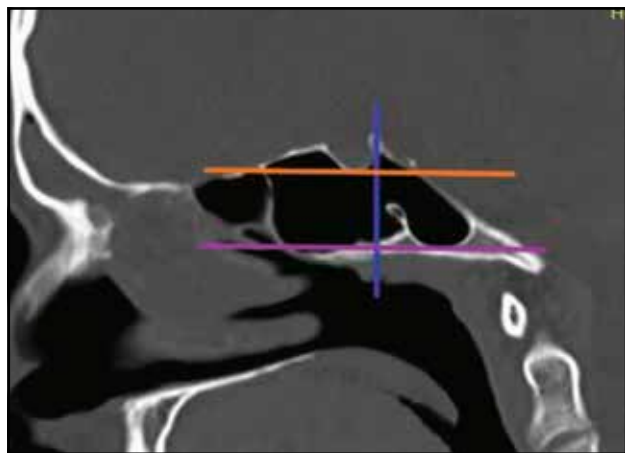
Dorsal extension - superiorly into the dorsum sella (cranio-facial CT scan, sagittal slice; purple horizontal line - the vidian canal, orange horizontal line - the inferior margin of the sella, blue vertical line - the posterior wall of the sella).
